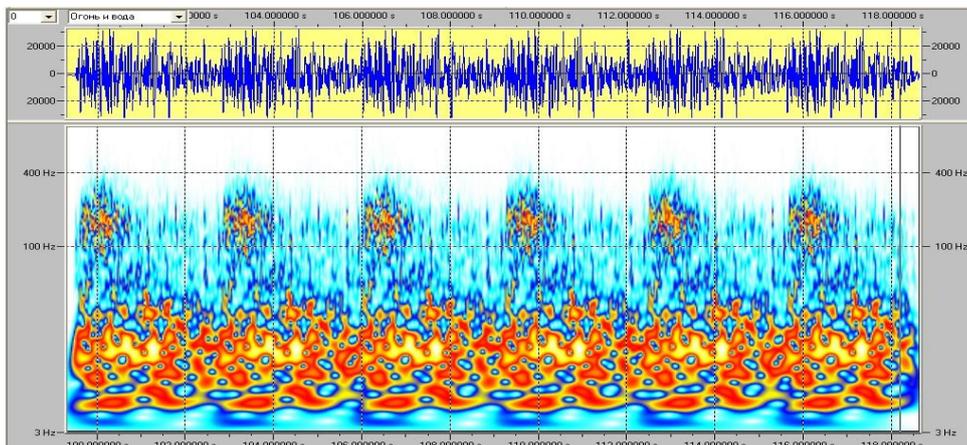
Acoustic sonogram of puerile respiration recorded in a 4-year-old child. Frequency range 3-500 Hz
